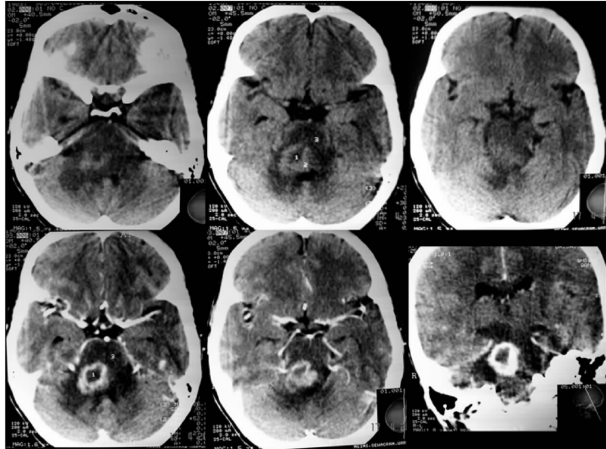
CT scan showing mildly hyperdense lesion on plain in the midbrain and pons with ring enhancement after contrast administration with significant peri-lesional oedema
